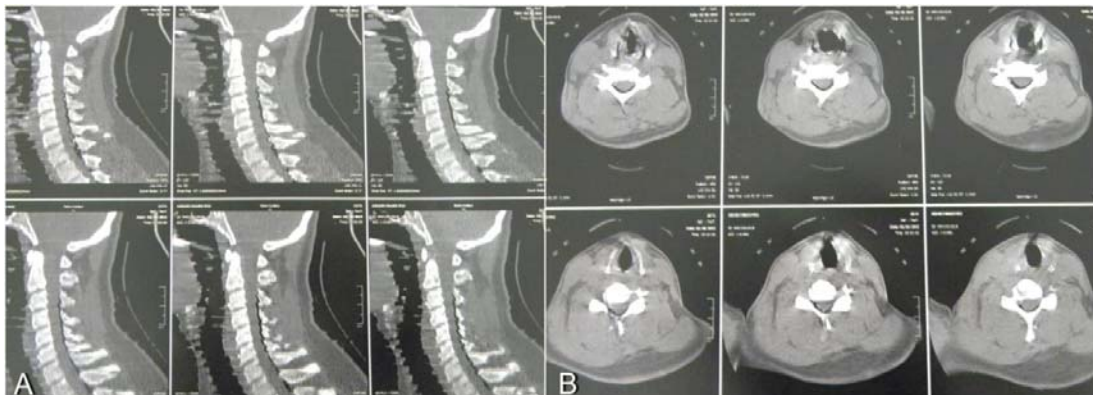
Sagittal multilane reformatted spinal CT images demonstrating traumatic cervical PR (A). Axial CT scan of the cervical spine shows extradural air collection in the dorsal spinal canal.
